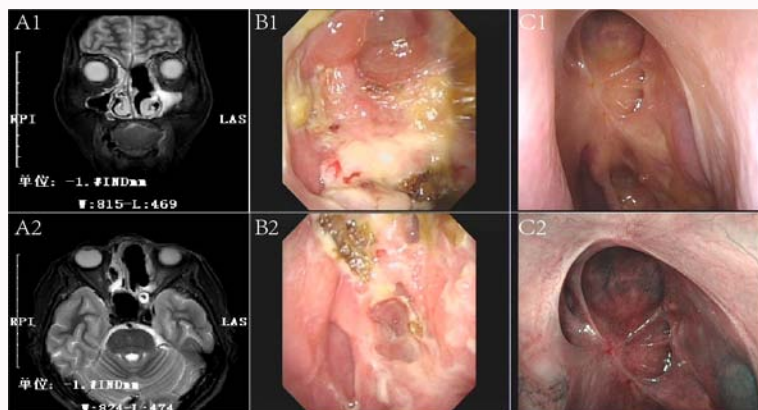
Postoperative reexamination. (A1-2) MRI was reexamined one week after operation showed that the tumor has been removed. (B1-2) Nasal endoscopy was reviewed two weeks after operation showed that nasal discharge and mucosa edema. (C1-2) Nasal endoscopy was reviewed one year after operation showed that nasal mucosa was epithelialized without tumor recurrence.
